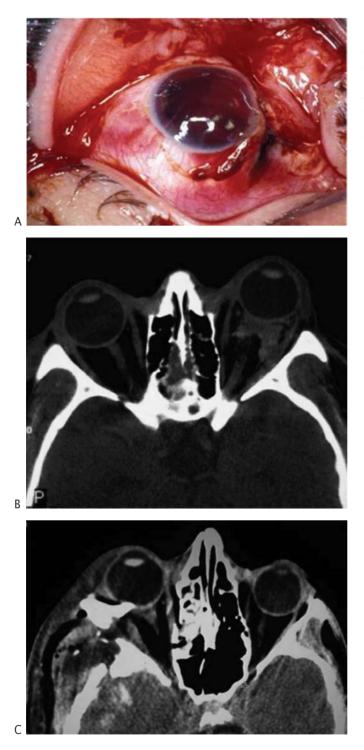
(A) Traumatic globe rupture with full-thickness scleral defect. (B) Axial computed tomographic (CT) image demonstrating left orbital hemorrhage, proptosis, and mechanical stretching of the optic nerve. (C) Axial CT image showing right intraorbital bone fragment.
